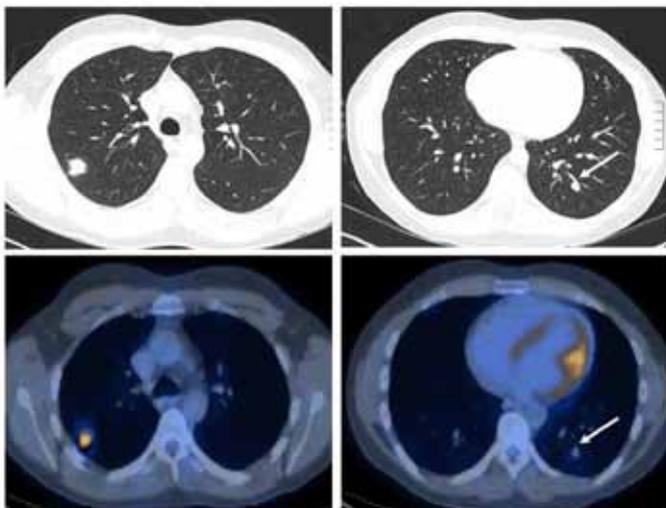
Computed tomography scan showing right upper lobe and left lower lobe lesion. Positron emission tomography (PET) scan reveals PET positive lesion in right upper lobe lesion.
